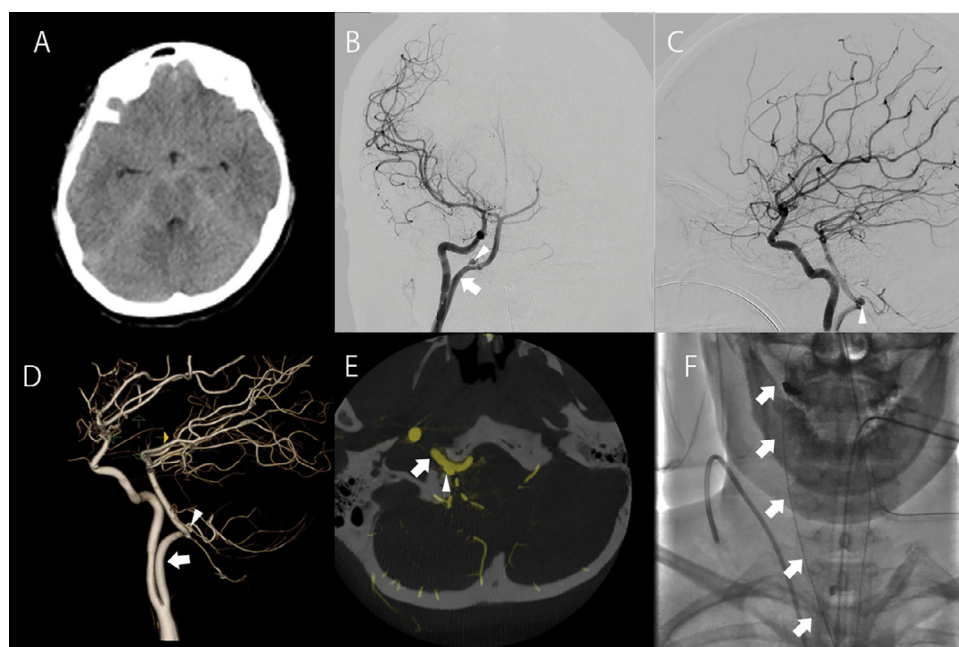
(A) A head computer tomogram showing thin subarachnoid hemorrhage in the interpeduncular cistern. (B) A frontal view of right internal carotid angiogram showing PPHA (a white arrow) and an aneurysm (an arrowhead) in the proximal to the PICA. (C) A lateral view of the right internal carotid angiogram. (D) A three-dimensional digital subtraction angiogram of right internal carotid artery (lateral view). (E) The maximum intensity projection axial image of a right internal carotid angiogram. (F) A image of the roentgen showing a guidewire through the CCA, ICA, and PPHA, which indicates minimum curvature of the artery. The white arrows indicate the guidewire. The CCA to the PPHA is almost straight.
